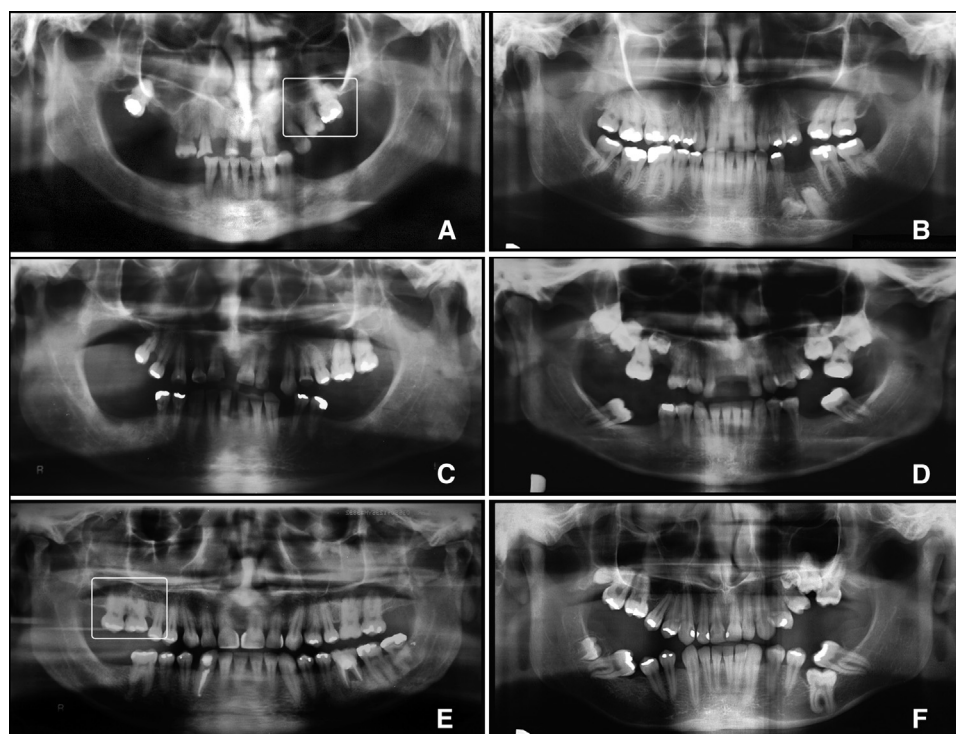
Panoramic radiographs of various members of the family during the follow-up period, showing the phenotypic variability: A, patient I.2 (male) at age 62; B, patient II.3 (male) at age 32; C, patient II.5 (male) at age 47; D, patient II.8 (female) at age 21; E, patient II.11 (male) at age 37; F, patient II.12 (male) at age 20.
